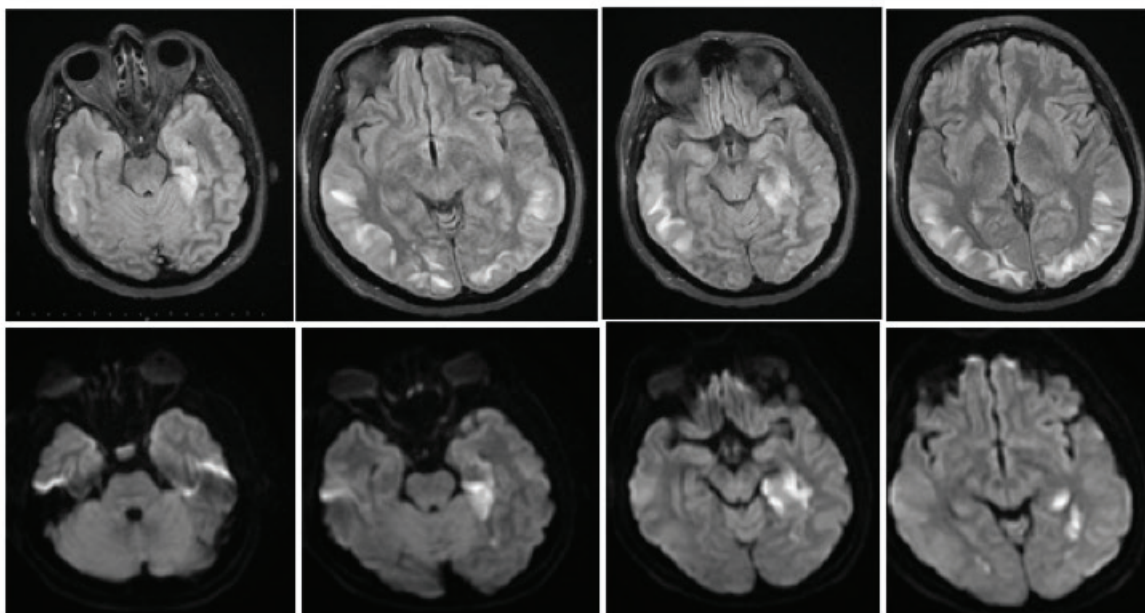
Patient's first Brain MRI Findings.
